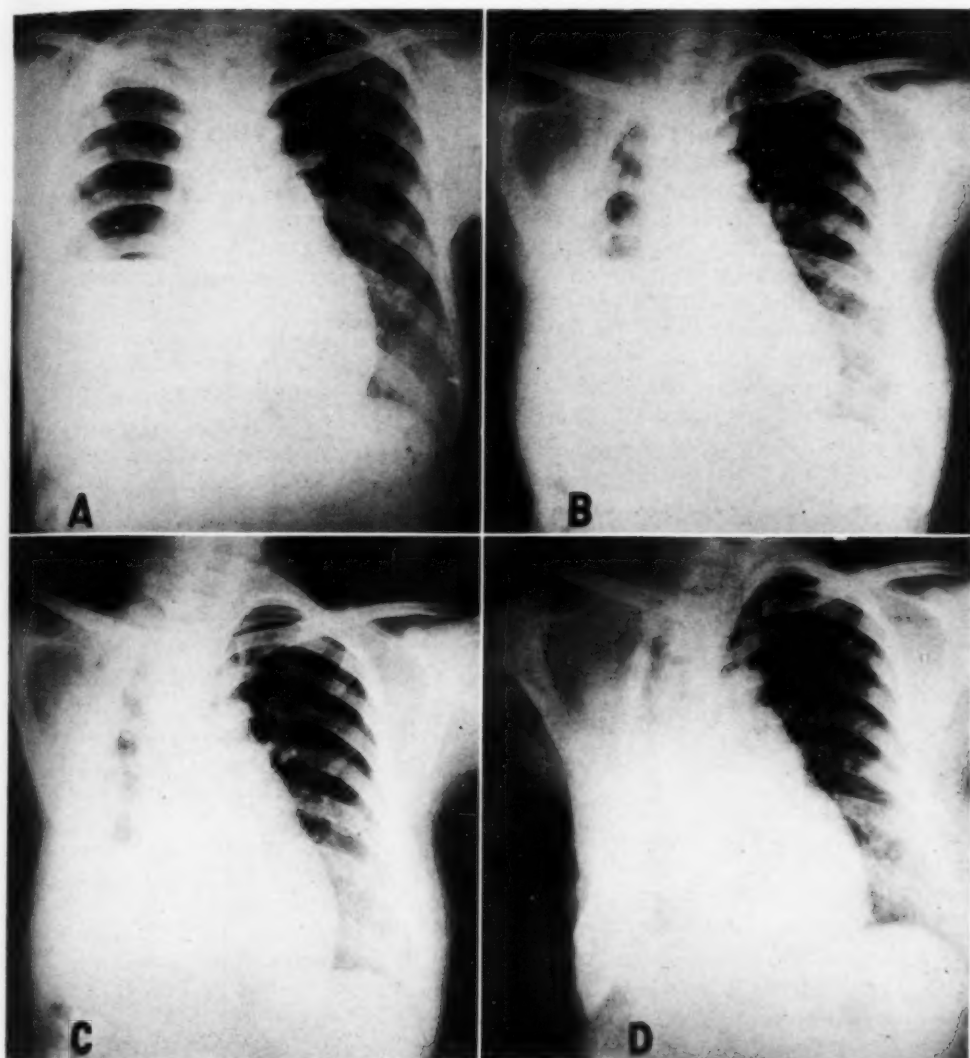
A. Roentgenogram showing complete collapse of lung, fluid level and fibrin deposits on the pleurae. (Pyopneumothorax.) B. Roentgenogram of same patient following total thoracoplasty for empyema, showing generalized convexity of regenerated chest wall. Recurrence of fluid and air aspirated preoperatively. C. Roentgenogram of same patient following further operative procedures to obliterate pleural empyema space; generalized convexity persists. Presence of patent bronchopleural fistula confirmed by noting positive intrapleural manometric readings. D. Roentgenogram of same patient following Schede operation, showing obliterated pleural empyema space. Sputum had always been negative following total collapse of lung by pneumothorax.
